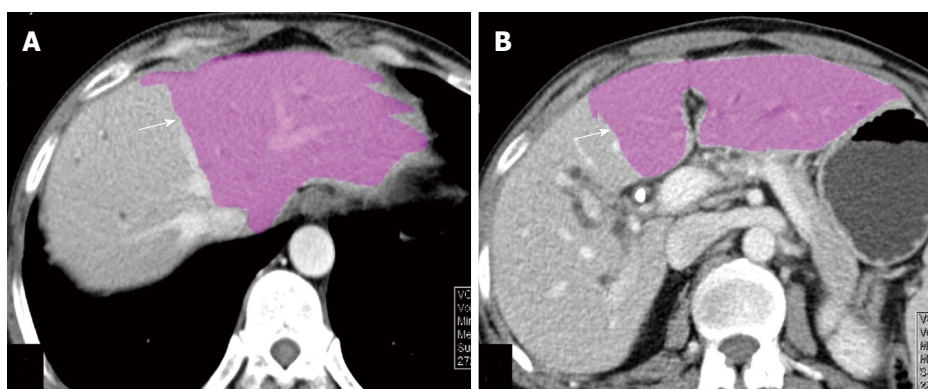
Axial venous phase computed tomography images (A and B) showing automated volumetry map with colour coding indicating the volume of future liver remnant (arrow).
